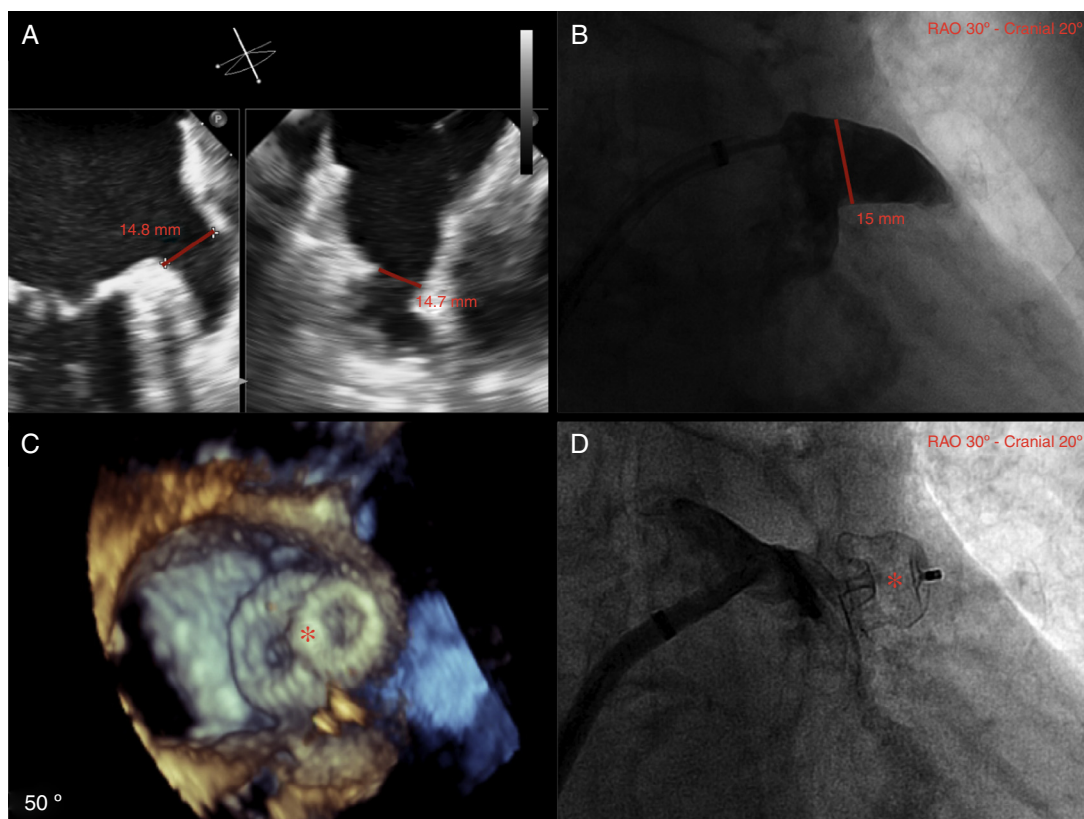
(A) Left atrial appendage (LAA) size by biplane two-dimensional transthoracic echocardiography (TEE); (B) LAA size by angiography (windsock morphology); (C) three-dimensional TEE showing complete occlusion of the LAA with the Amulet device (red asterisk); (D) angiography showing complete occlusion of the LAA with the Amulet device (red asterisk).
